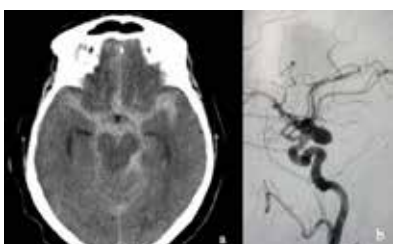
Subarachnoid hemorrhage in non-contrast brain CT and saccular aneurysm at the left ICA distal end in DSA.
